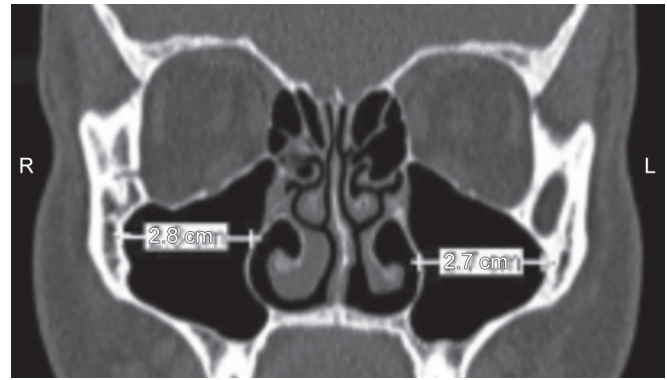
Coronal section of maxillary antrum CBCT image showing maximum MD dimension
